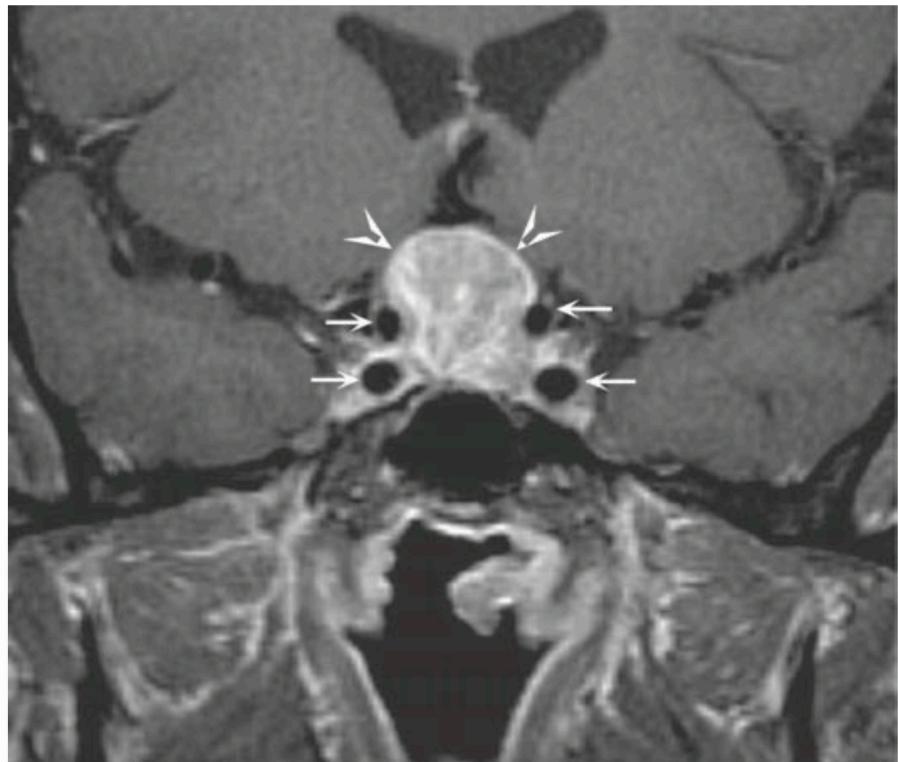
Pituitary adenoma. Coronal T1-weighted postcontrast magnetic resonance image shows a homogeneously enhancing mass (arrowheads) in the sella turcica and suprasellar region compatible with a pituitary adenoma; the small arrows outline the carotid arteries.
